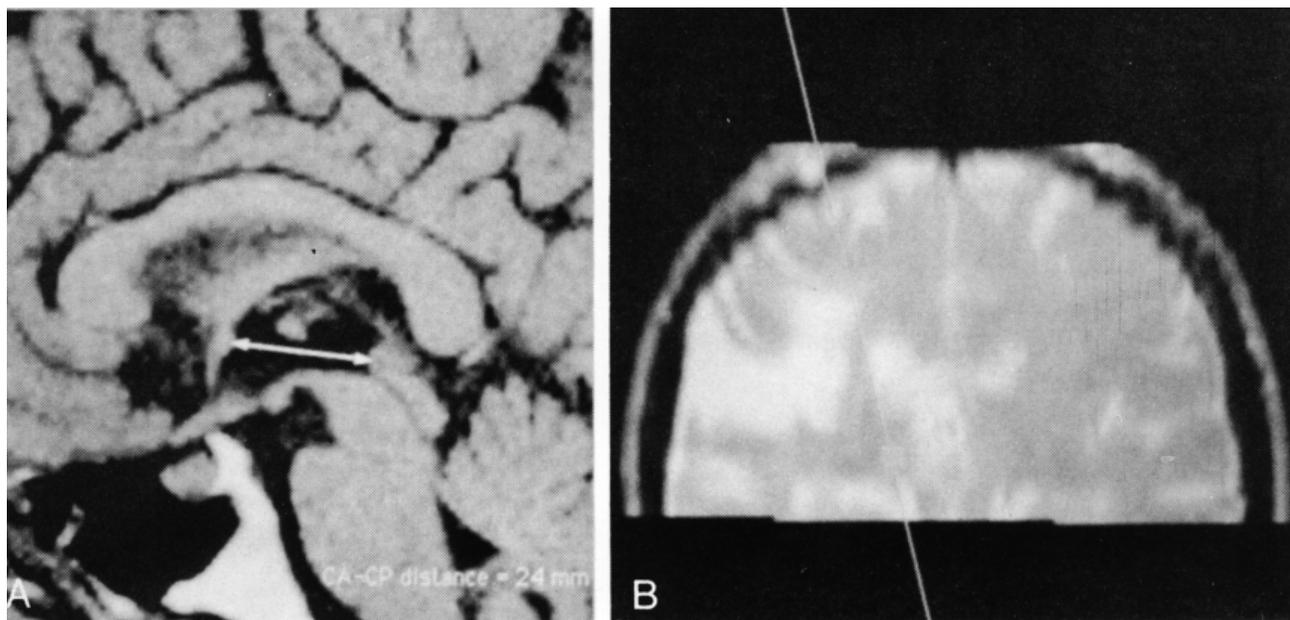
Case report 2 (A) CA-CP as determined on MRI (T_1 -weighted axial topogram). (B) Electrode trajectory through target as determined with stereotactic workstation (with permission).
